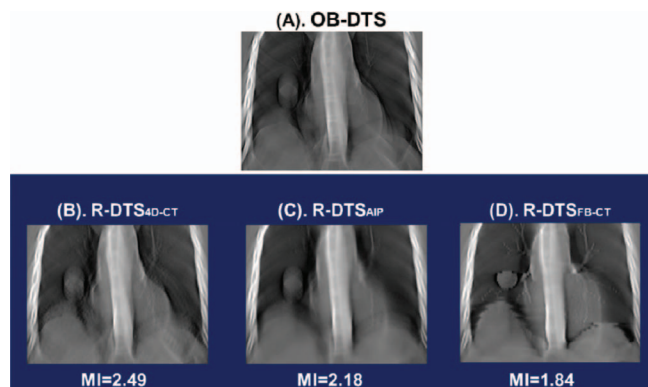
Figures of 30° OB-DTS [panel (A)] and corresponding R-DTS_{4D-CT} [panel (B)], R-DTS_{AIP} [panel (C)], and R-DTS_{FB-CT} [panel (D)] with AP scan direction for 30 mm target in the middle of lung, with $\text{RC} = 5$ s and $\text{FX} = 1$.
